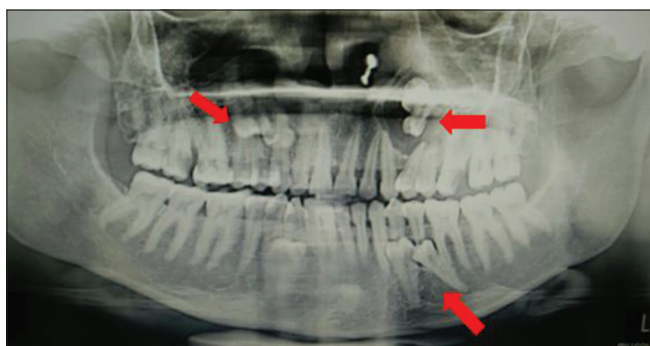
Orthopantomogram showing the well-circumscribed radiolucent lesion with distinct, radiopaque margins, and the multiple impacted supernumerary teeth
